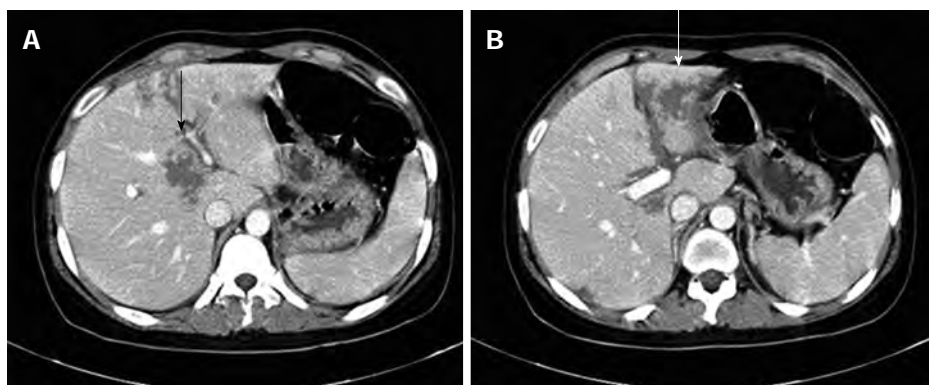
Intraparenchymal hemorrhage in the liver (arrows). An abdominal computed tomography showed multiple low attenuated lesions without peripheral enhancement (A) and perilesional edema of the liver on the contrast-enhanced image (B).
